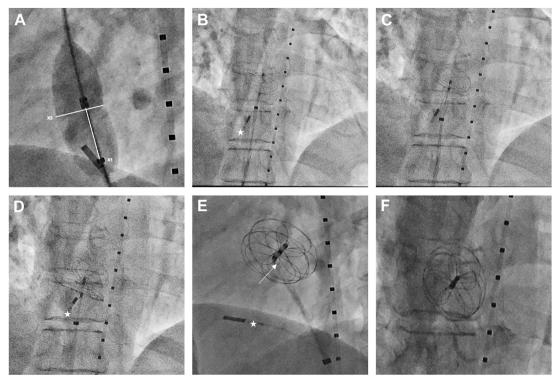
Intracardiac echocardiography guided implantation of a Gore Cardioform Septal Occluder for a small atrial septal defect (ASD). (A) Balloon sizing of ASD using Biplane measurements, X1: 15-mm length between balloon dots, X2: ASD size based on balloon indentation. (B) Deployment of left atrial disc. (C) Flattening of left atrial disc on the atrial septum. (D) Deployment of right atrial disc. (E) Locking loop (arrow). (F) Device released. *Intracardiac echocardiography catheter.
